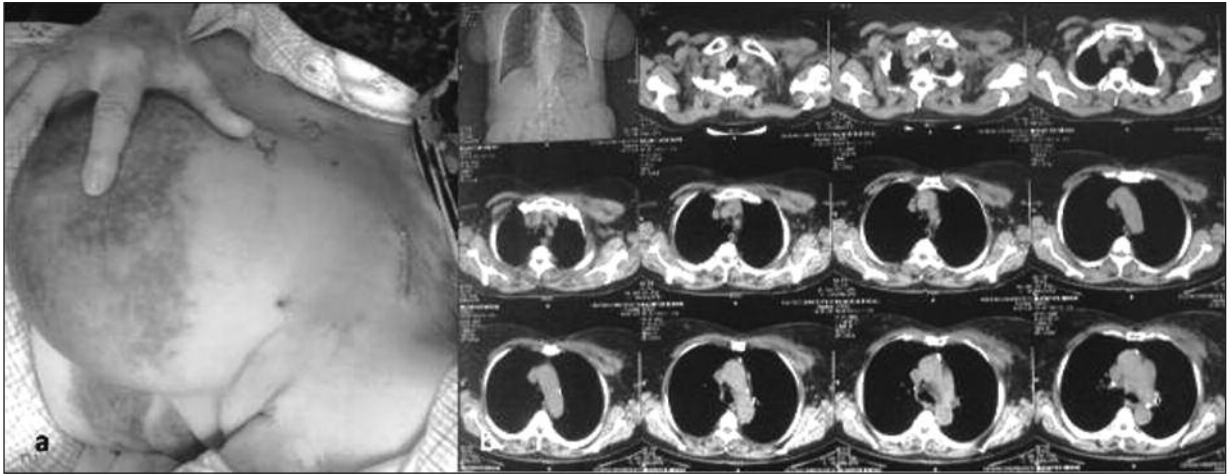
a. Postoperative appearance of patient b. Control thoracic CT that revealed no collections in the postoperative period .
